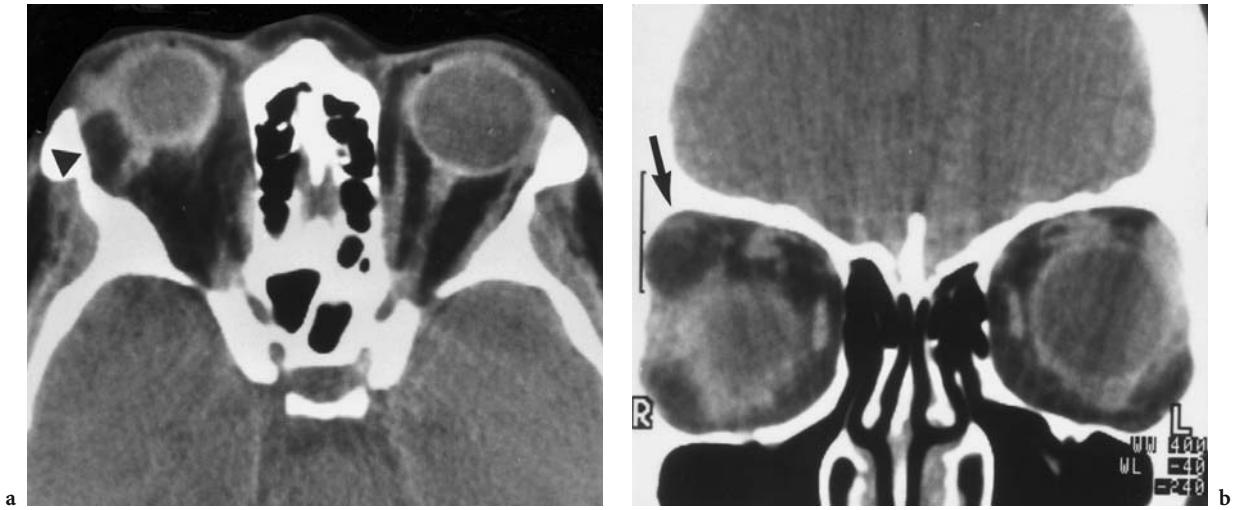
A 32-year-old woman with slowly progressing, painless, eccentric, inferior proptosis of the right eye. Diagnosis: epidermoid of the lacrimal gland. CT: a Axial view, with a hypodense (fatty) mass in the superior lateral orbit (*arrowhead*), displacing the globe inferiorly. Note the impression of the zygomatic bone. b Coronal view, demonstrating the communication with the upper lacrimal gland (*arrow*)
